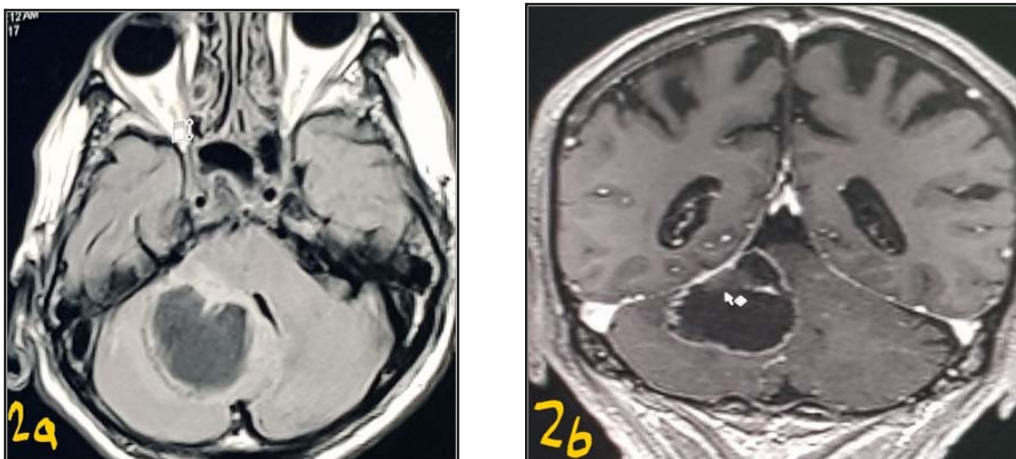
(a) T1WI Axial plane MRI through the posterior fossa shows well defined, low signal intensity cystic lesion seen in left cerebellar hemisphere, (b) Coronal T1WI post contrast shows enhanced mural nodule, features of hemangioblastoma.
